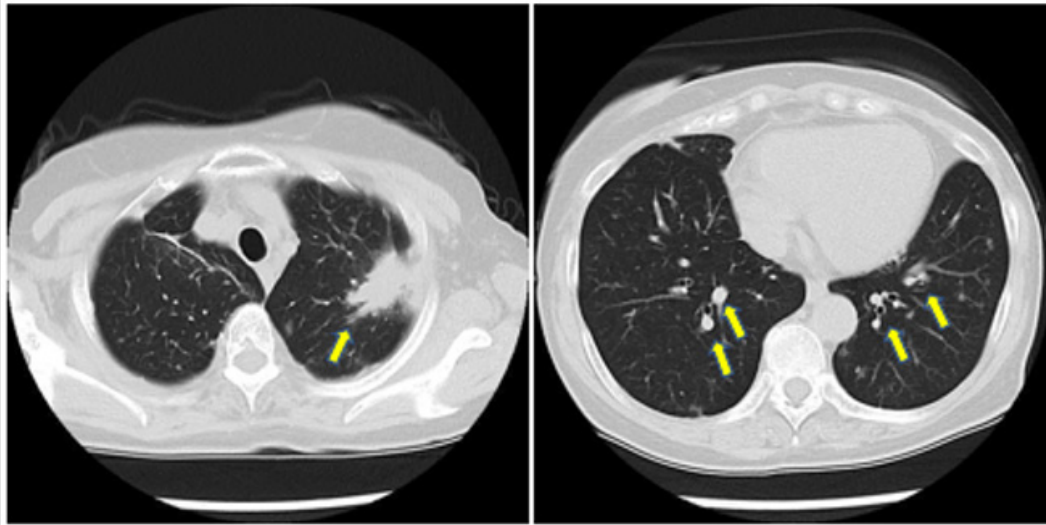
Chest computed tomography was consistent with predominant solid lesion in left upper lobe and multiple pulmonary nodules.
